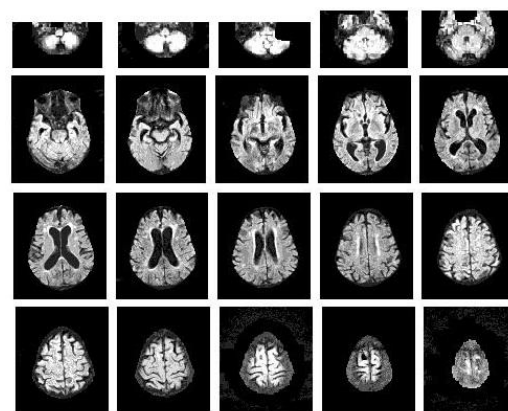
MRI scans post segmentation (Sample 4)
